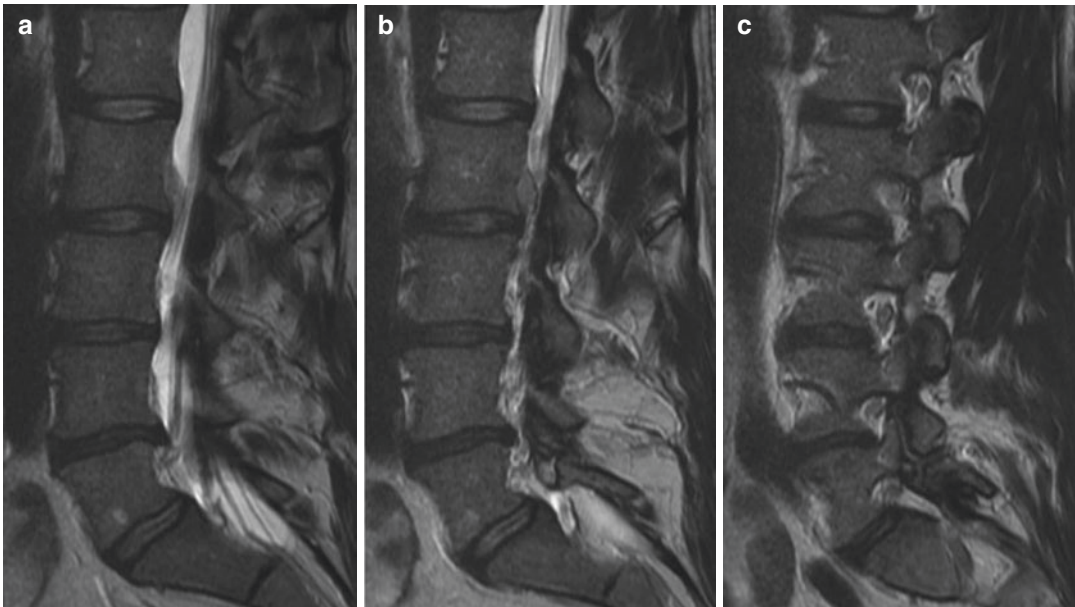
Right L2–L3 foraminal disc extrusion with superior migration into the neural foramen compressing the exiting right L2 nerve root. (a, b, c) Sagittal T2-weighted MR images; (d, e) Axial T2-weighted MR images
